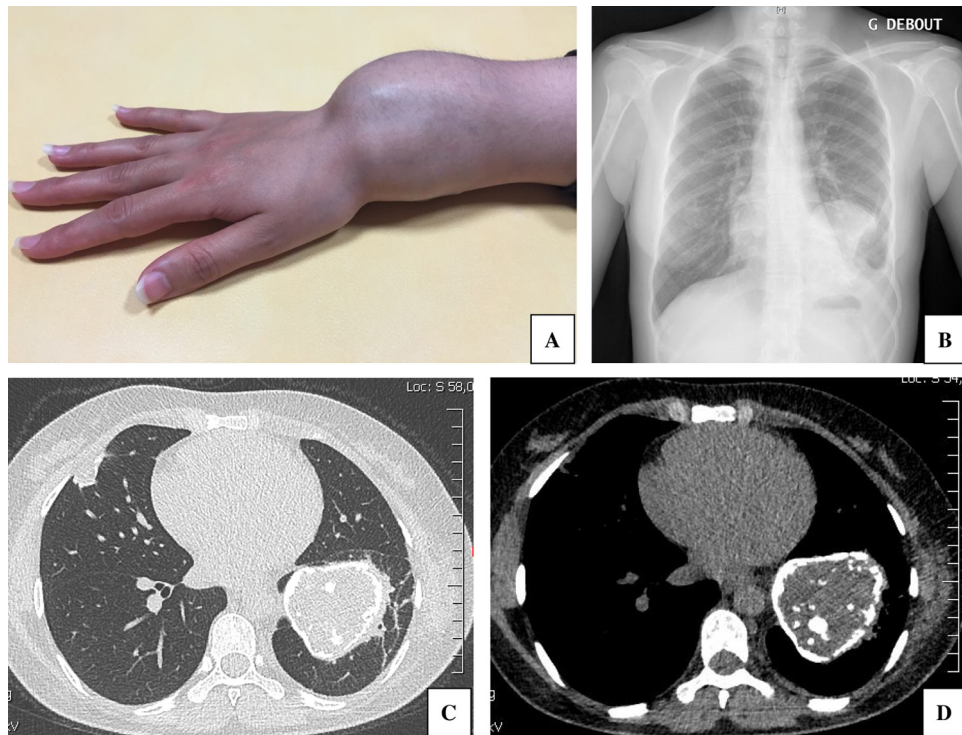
A. Swelling of the right wrist. B. Chest X-ray showing the opacity of the left lower lobe. C. Chest soft tissue CT scan showing bilateral nodules and mass. D. Chest mediastinal CT scan showing the partially calcified pulmonary mass.
